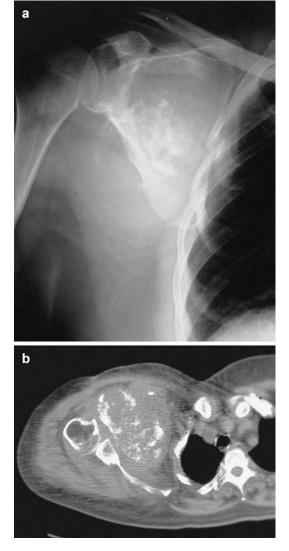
(a, b) Extraskeletal mesenchymal chondrosarcoma of the right axilla in a 50-year-old man: (a) plain radiograph; (b) CT. Ill-defined mass with coarse intralesional calcifications located in the subscapular region (a, b). Calcifications are commonly seen in the mesenchymal type of extraskeletal chondrosarcoma
